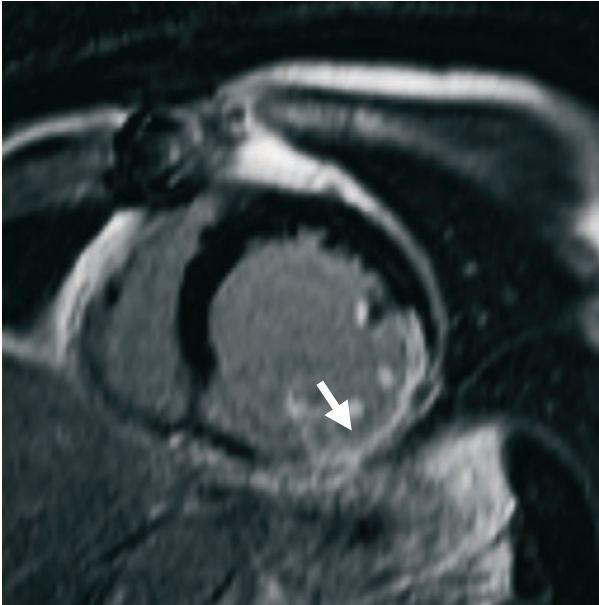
Contrast-enhanced MRI of a patient with transmurular scar tissue in the postero-lateral wall.
